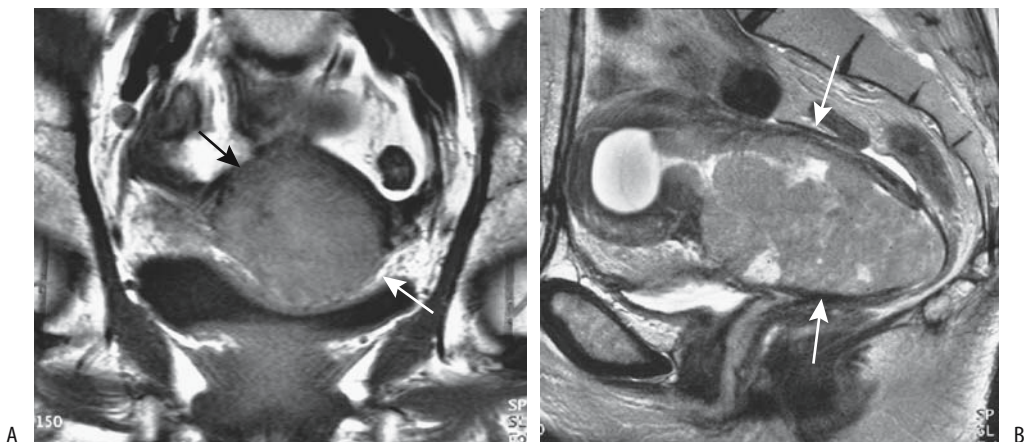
Endometrial carcinoma. A: Coronal T1-weighted MR image reveals a uterine tumor (arrows). B: Sagittal contrast-enhanced image better identifies tumor size (arrows), including fluid in an obstructed fundus (arrowheads). (Source: Burgener FA, Meyers SP, Tan RK, Zaunbauer W. *Differential Diagnosis in Magnetic Resonance Imaging*. Stuttgart: Thieme, 2002, with permission.)
